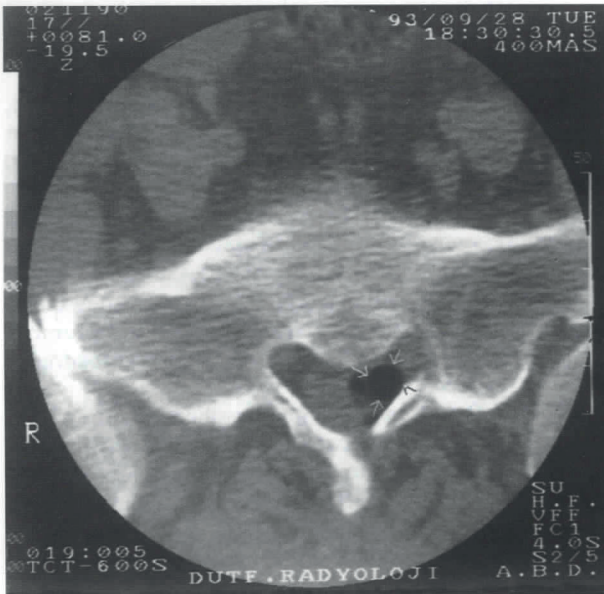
On CT, the gas bubble is seen anterolaterally within the spinal canal on the left side. CT reveals the relation between the gas bubble, the nerve root and the thecal sac. There is radicular compression due to herniated intradiscal gas.
